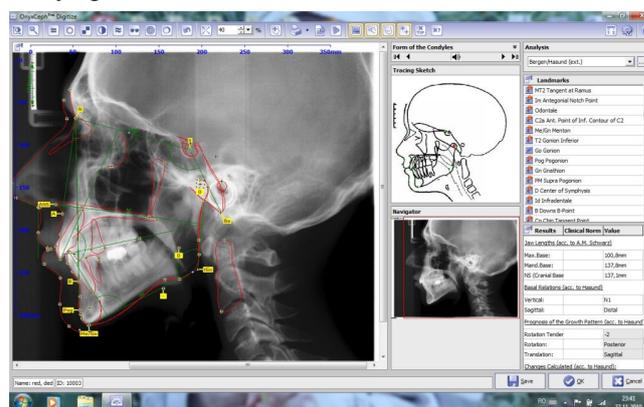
Cephalometric analyze of a digital radiography using a dedicated software
